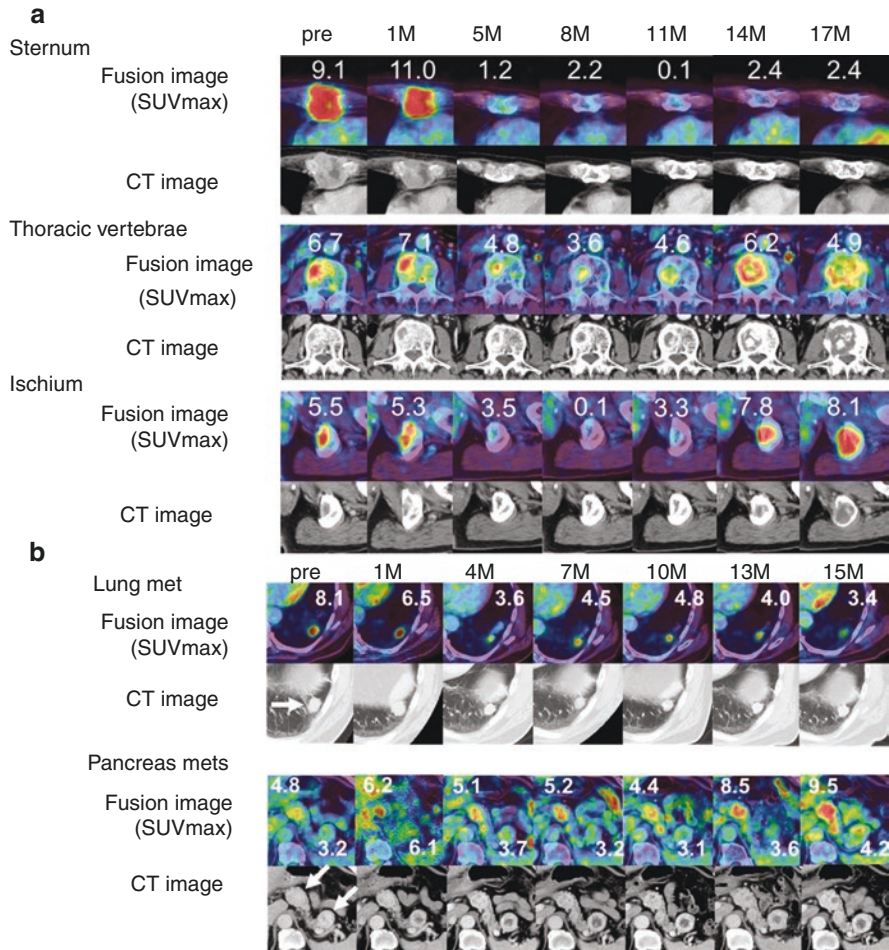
Sequential Assessment of RCC by FDG PET/CT during VEGFr-TKI treatment. (a) A patient with multiple bone metastases treated by VEGFr-TKI. The SUVmax of all bone metastases decreased temporally and increased before tumor was judged as PD at the 17th month. Fusion images were upper lanes. The number means SUVmax of each lesion. CT images were lower lanes. “Pre” refers to pretreatment evaluation; “M” refers to month after TKI treatment started [26]. (b) A patient with lung and pancreas (head and tail) metastases treated by VEGFr-TKI. The SUVmax of lung metastasis had suppressed during treatment, but the SUVmax of pancreas head metastasis increased before tumor was judged as PD at the 15th month. Fusion images were upper lanes. The number means SUVmax of each lesion. CT images were lower lanes. “Pre” refers to pretreatment evaluation; “M” refers to the number of month after TKI treatment started [26]
